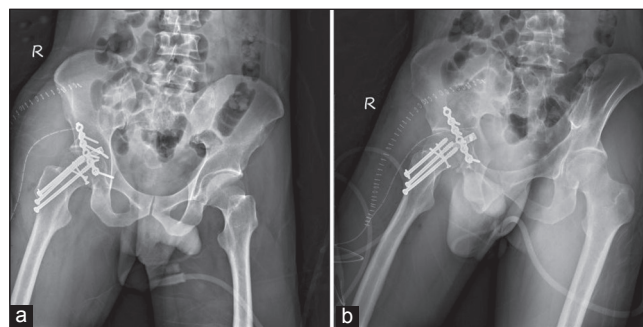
Postoperative radiography showed anatomic reduction and satisfactory internal fixation of all fractures
